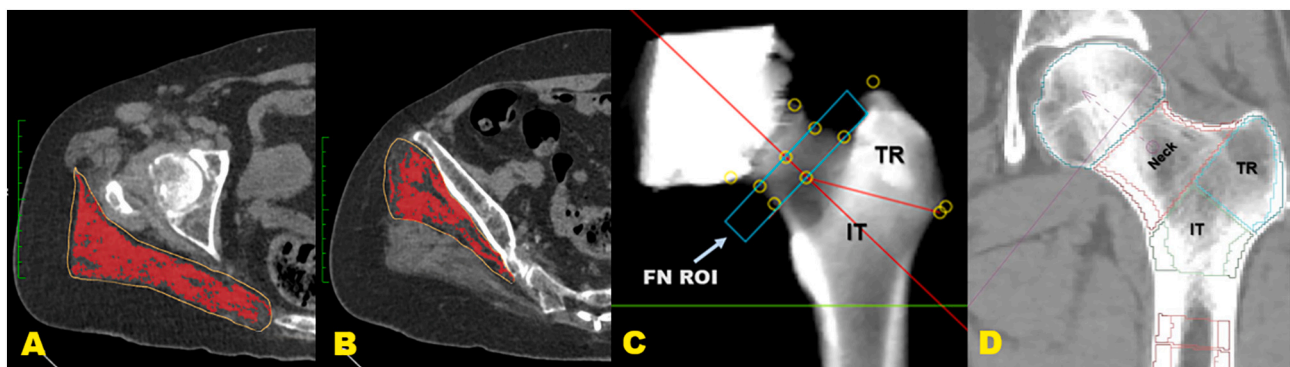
A representative case with second hip fracture. (A) Measurement of cross-sectional area and mean computed tomography values of the gluteus maximus muscle at the level of the greater trochanter. (B) Measurement of the gluteus medius and minimus muscle at the third sacral level. Muscle region is represented by the area highlighted in red. The gluteus minimus muscle has undergone complete fatty infiltration. (C) Regions of interest (ROIs) analyzed in the proximal femur by QCTPro CTXA. (D) Femoral neck cortical thickness measured by MIAF Femur.
